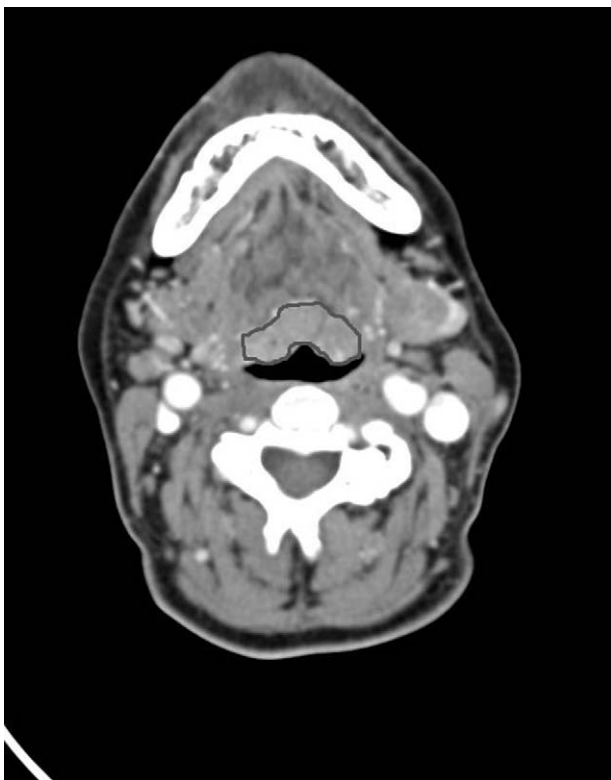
Pre-operative neck and chest CT showing LT hypertrophy marked with a gray contour line. CT=computed tomography, LT=lingual tonsil.
